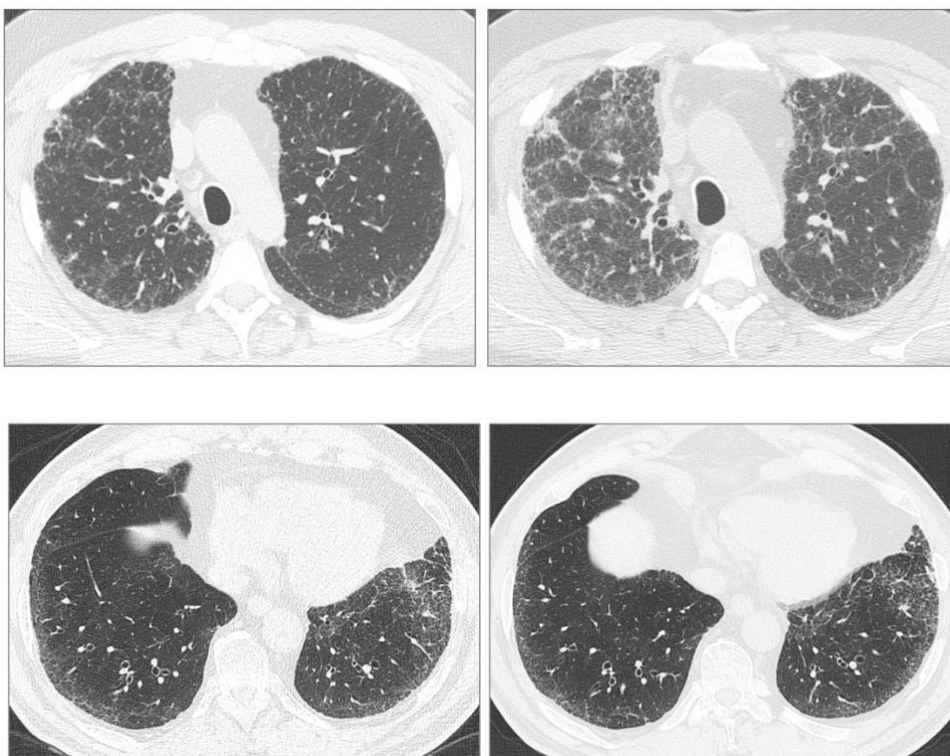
Axial HRCT images of two patients: a 53 year-old male with a progression of disease (patient 1) (a, b) and a 63 year-old male with stable disease (patient 2) (c, d). Patient 1: HRCT at treatment start (a) and after one year of treatment (b) demonstrating a significant progression of ground glass opacities and reticulation. Patient 2: HRCT at treatment start (c) and after one year of treatment (d) demonstrating stability of ground glass opacities and reticulation.
